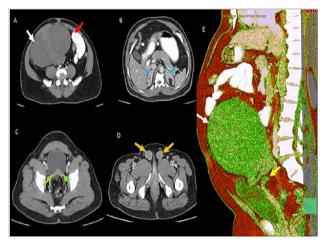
CT abdomen and pelvis with IV and oral contrast portovenous phase A and E. Axial and E Sagittal cuts color-coded 3D rendering demonstrating a large heterogeneous enhanced right paramedian abdominal soft tissue mass (white arrows), displacing the bowel loops peripherally (red arrow). The mass is connected to the retro-vesical plate-like soft tissue density by a twisted pedicle (yellow arrow). Soft tissue enhancing structure seen posterior to the urinary bladder (Green arrows) and 7 bilateral implanted testes (Orange arrows).
